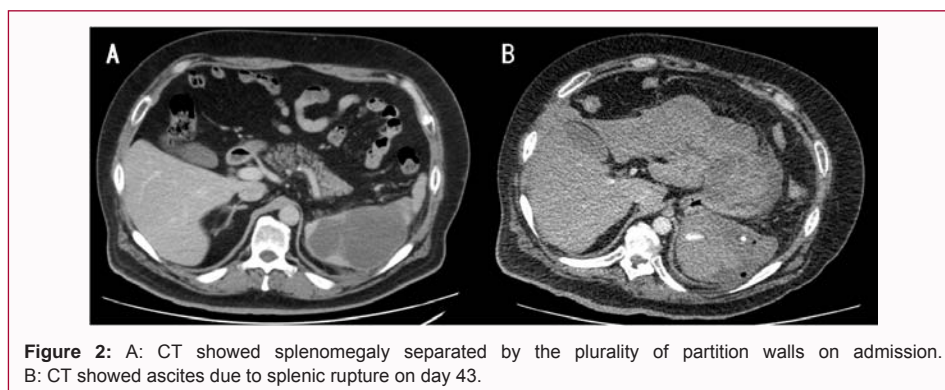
A: CT showed splenomegaly separated by the plurality of partition walls on admission. B: CT showed ascites due to splenic rupture on day 43.
